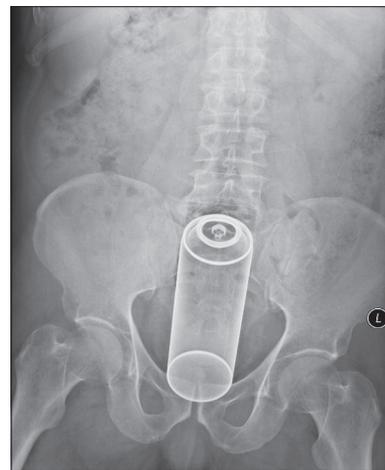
An abdominopelvic roentgenogram showed a bottle of deodorant
